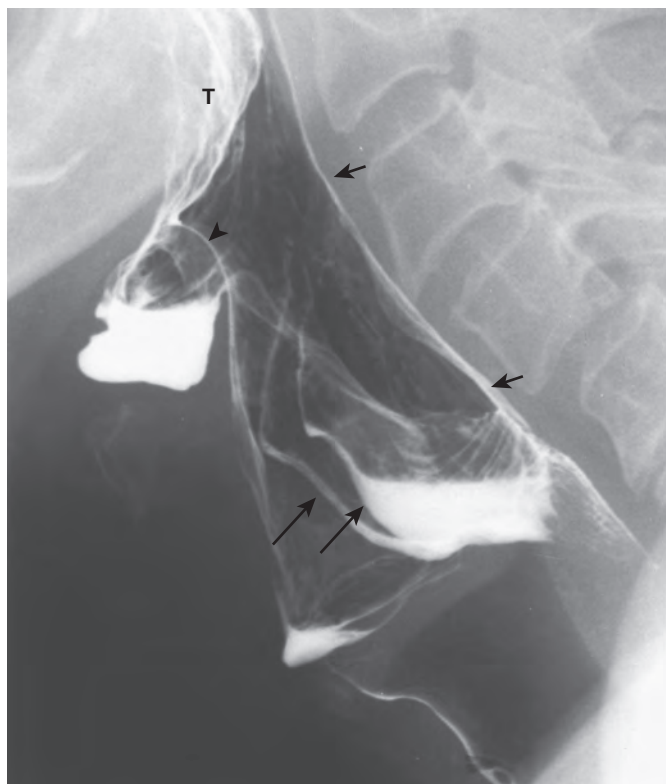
Radiograph of the pharynx with the patient in a right lateral position, facing the examiner. The lateral view is the best view to demonstrate the vertical surface of the tongue (T), epiglottic tip (arrowhead) and aryepiglottic folds, anterior walls of the piriform sinuses (long arrows), and posterior pharyngeal wall (short arrows). Opening of the pharyngoesophageal segment is shown only during swallowing. This static radiograph shows that swallowing is abnormal because barium fills the laryngeal ventricle and coats the proximal trachea; it does not demonstrate why barium entered the larynx.
